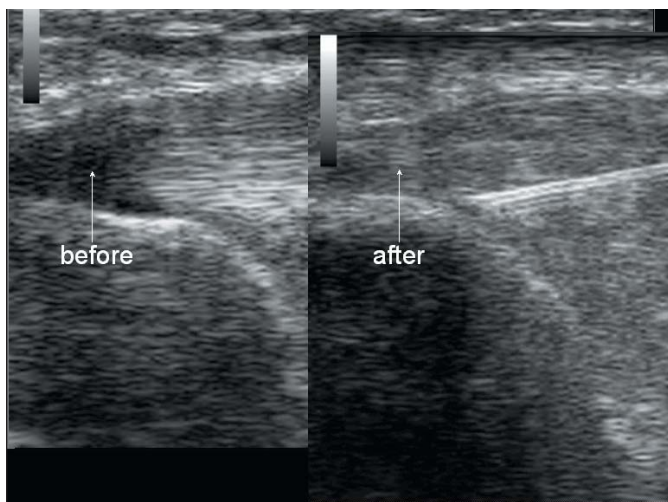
Ultrasound images before and after PRP injections treatment.*
